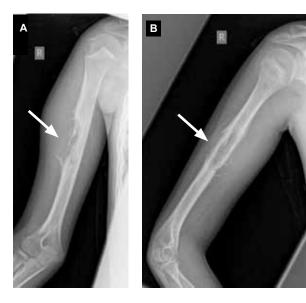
Anterior-posterior (A) and lateral (B) radiographs demonstrating a humeral diaphyseal lesion with extensive cortical destruction, soft tissue mass extension, and periosteal reaction.
